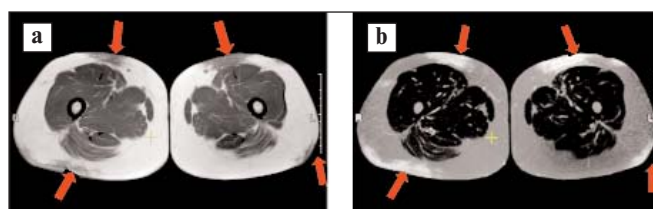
MRI of the thigh soft tissues: a – in T1-mode, the hypointensity (arrows) is detected, exhaustion of subcutaneous fat septal structure; b – In STIR T2-mode, nonhomogeneous increase in the intensity of the MR-signal is detected – areas of edema (arrows)
